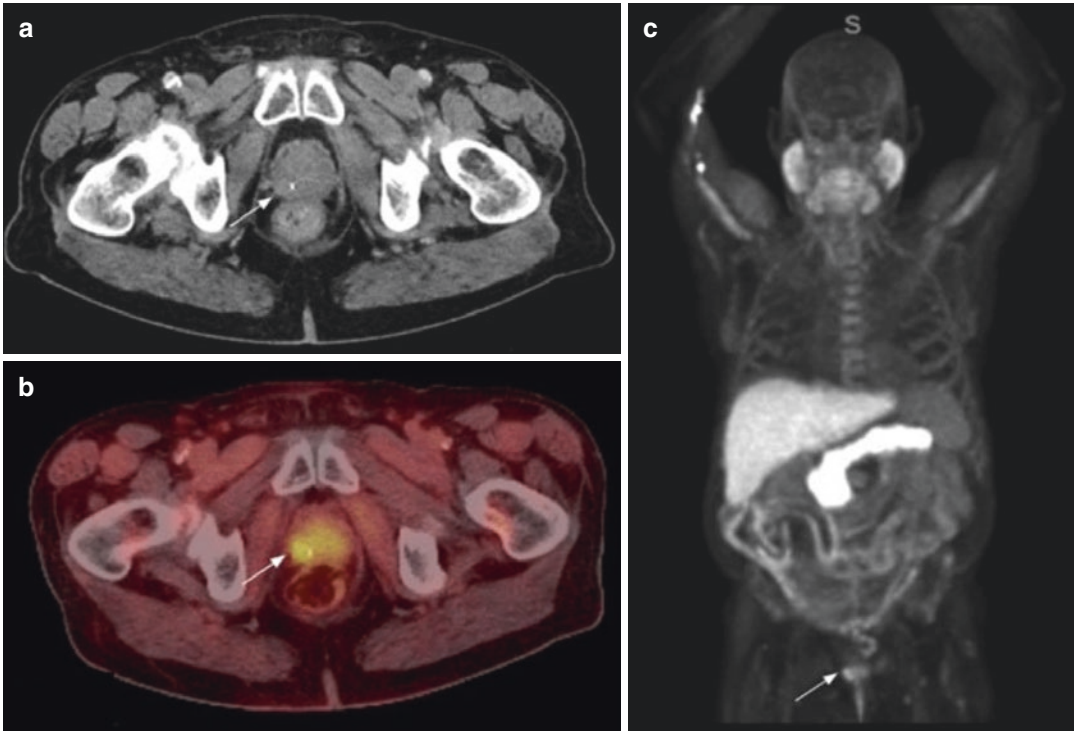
A 65-year-old male with prior history of prostate cancer diagnosed 7 years ago (Gleason 4 + 3 = 7) status post definitive radiation therapy with rising PSA of 2.9 ng/ml. CT body scan with contrast and bone scan were negative for recurrent disease. (a) Radiation seeds are
